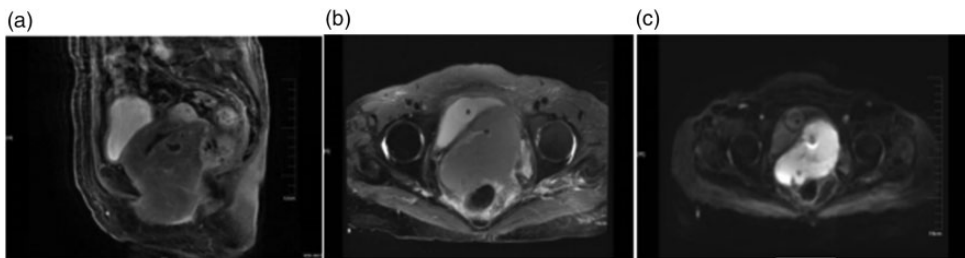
Magnetic resonance imaging scans of an 83-year-old female patient that presented with a pelvic mass for more than 1 month showed the following: (a) an enlarged uterus; (b) mild-to-moderate enhancement of the tumour on an enhanced scan. The enhancement was lower than that of the normal myometrium. There was no enhanced necrotic area in the lesion and (c) a high signal was observed on diffusion weighted imaging.
